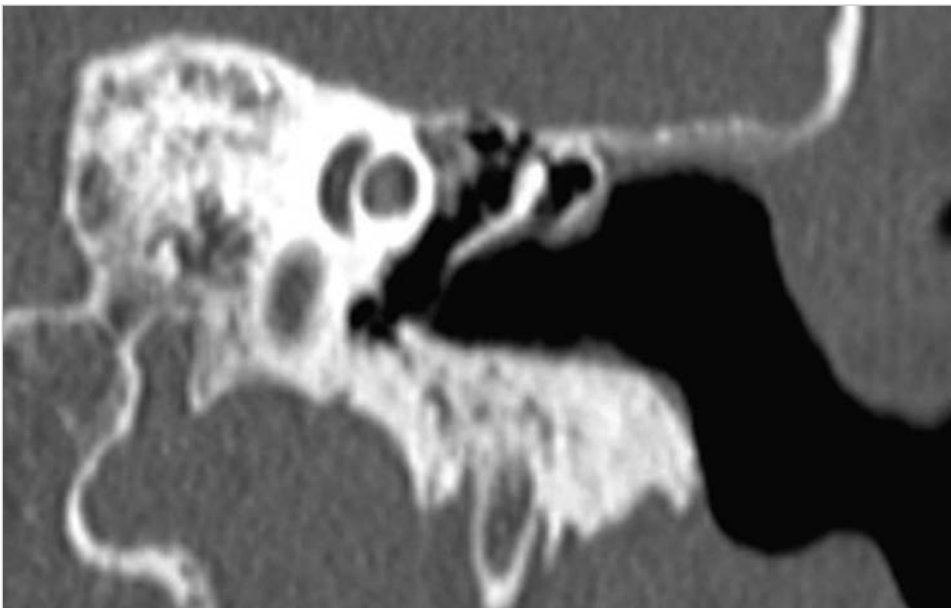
The postoperative coronal CT shows complete removal of the exostosis resulting in enlarged clear external auditory canal.
